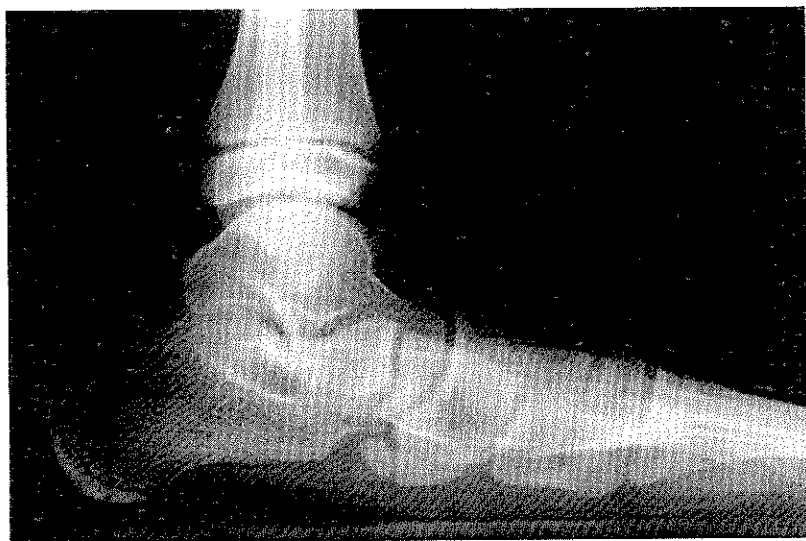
Preoperative radiograph showing increased talar declination, decreased calcaneal inclination angle, and talonavicular fault.
